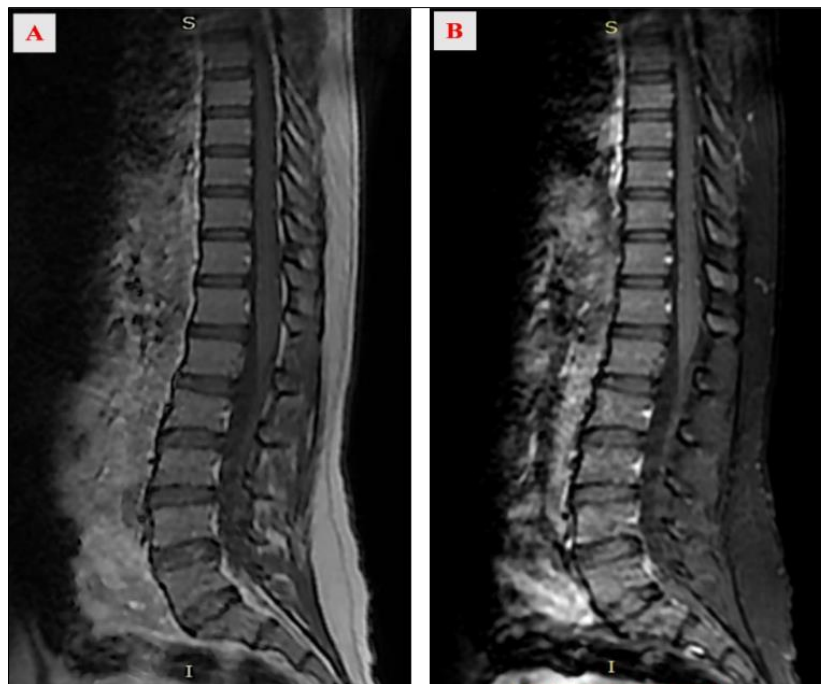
Follow-up MRI after one month with sagittal T1 sequences before (A) and after gadolinium injection (B), showing the disappearance of the intramedullary process. Final diagnosis: Acute transverse myelitis of thoracolumbar localization
